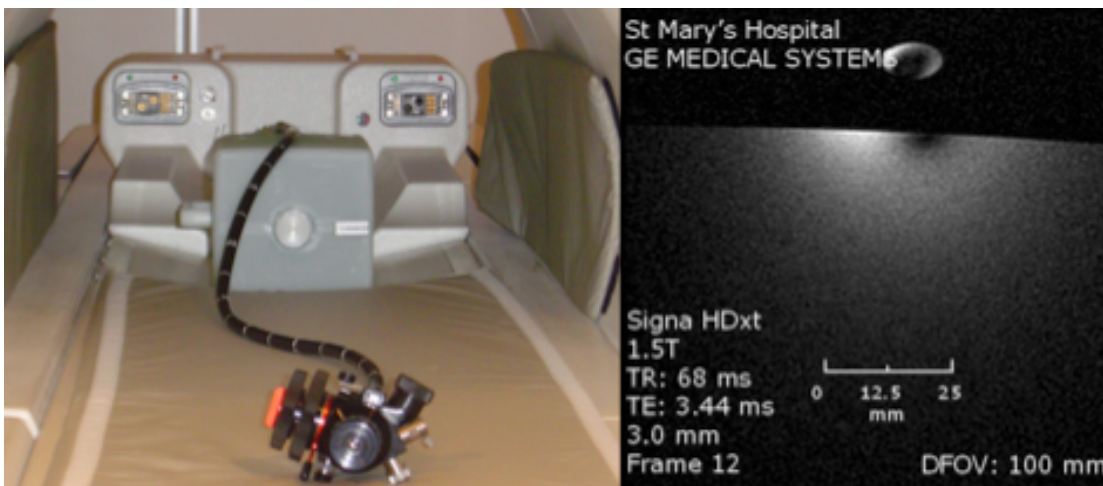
MR imaging with coil running through MR compatible duodenoscope
